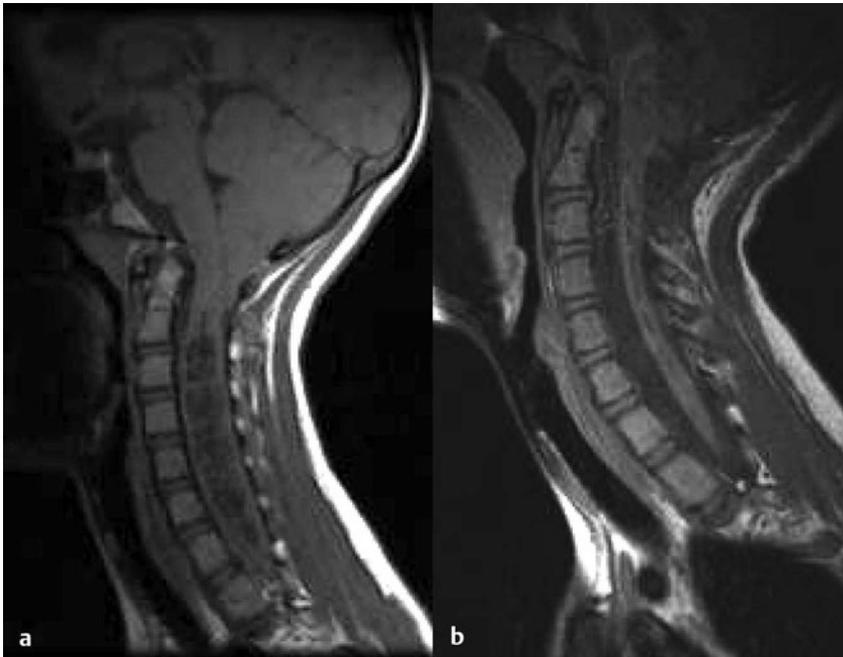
(a) Sagittal magnetic resonance image of a 14-year-old girl with a Chiari 1 malformation and holocord syringomyelia. (b) Note the syrinx resolution after posterior fossa decompression.
